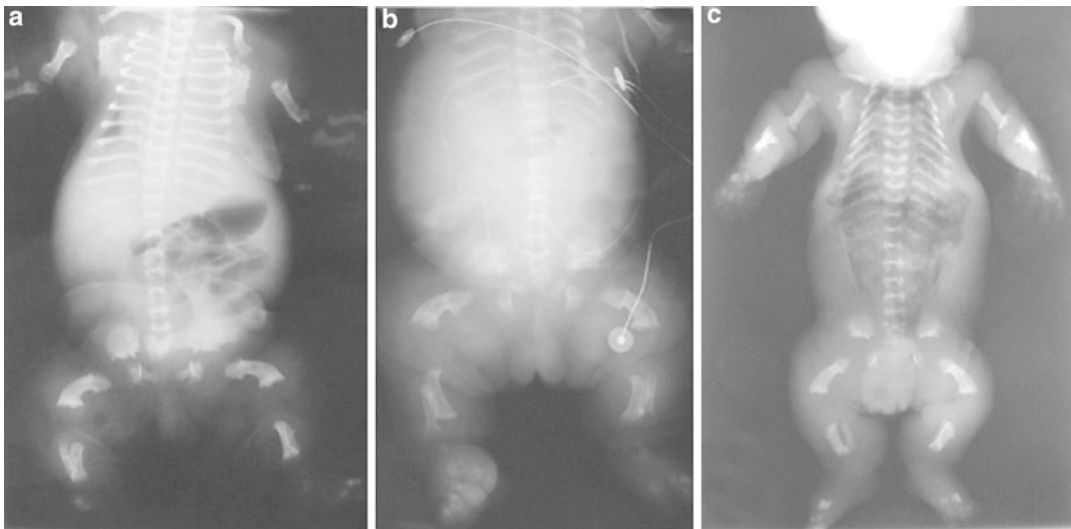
(a–c) AP radiographic views of three infants with typical findings of TDI showing profound platyspondyly, decreased thoracic volume, characteristic pelvic configuration, micromelia, and the so-called “telephone receiver” femoral bowing
